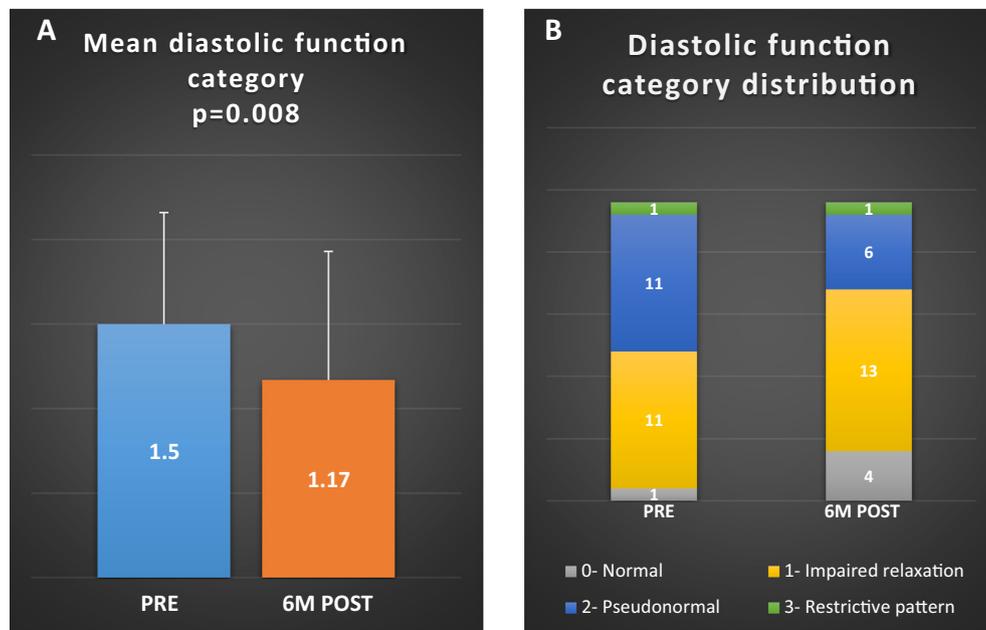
Echocardiographic parameters of diastolic function at baseline and 6 months following Reducer implantation. (2A) Mean diastolic function category at baseline and 6 months following Reducer implantation. (2B) Distribution of diastolic function categories at baseline and 6 months following Reducer implantation.
